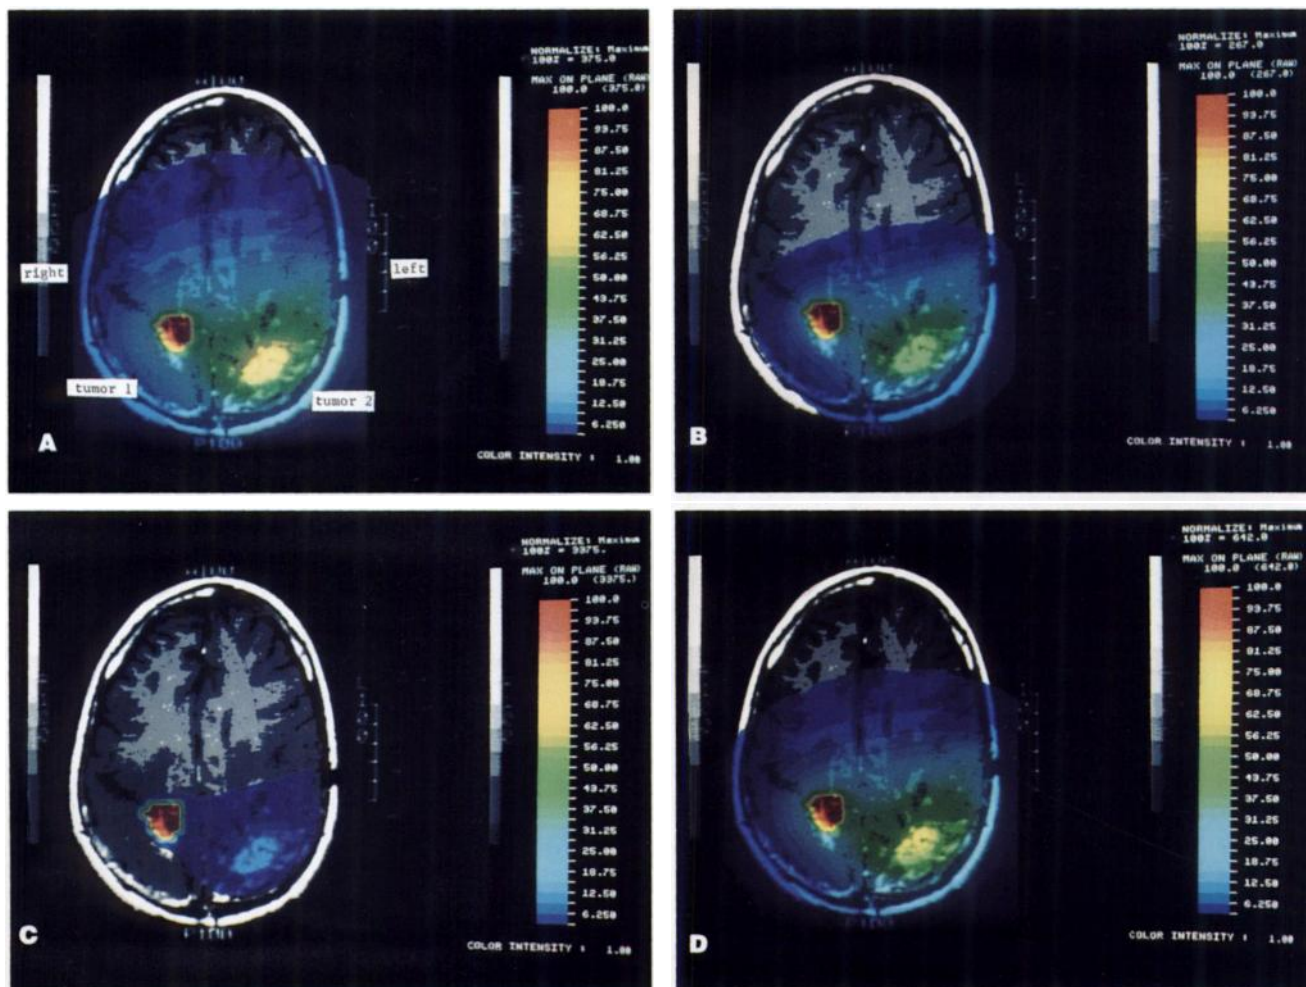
A colorwash display, superimposed on an MRI image of Patient 2, depicting spatial distribution of absorbed dose due to activity in Tumor 1 (on left) and Tumor 2 (on right), delineated using PET images. A cumulated activity concentration of $10^6 \text{ MBq}\cdot\text{sec}/\text{m}^3$ was assigned to both tumor activity volumes. (A) ^{131}I photon emissions, (B) ^{125}I photon emissions, (C) total ^{131}I emissions (electron and photon) and (D) both ^{131}I and ^{125}I photon emissions.
